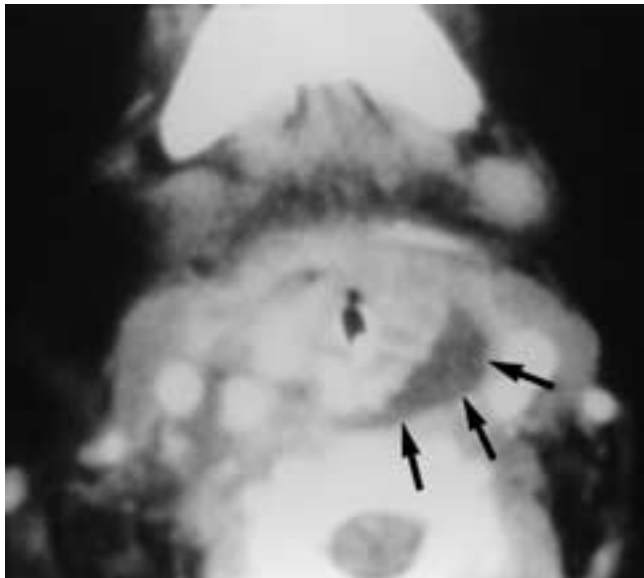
Axial contrast-enhanced CT scan shows a fluid collection in the retropharyngeal space (arrows). The lack of a thick, enhancing wall does not exclude a retropharyngeal abscess and, in our experience, an enhancing wall is rarely present in a retropharyngeal space abscess.
